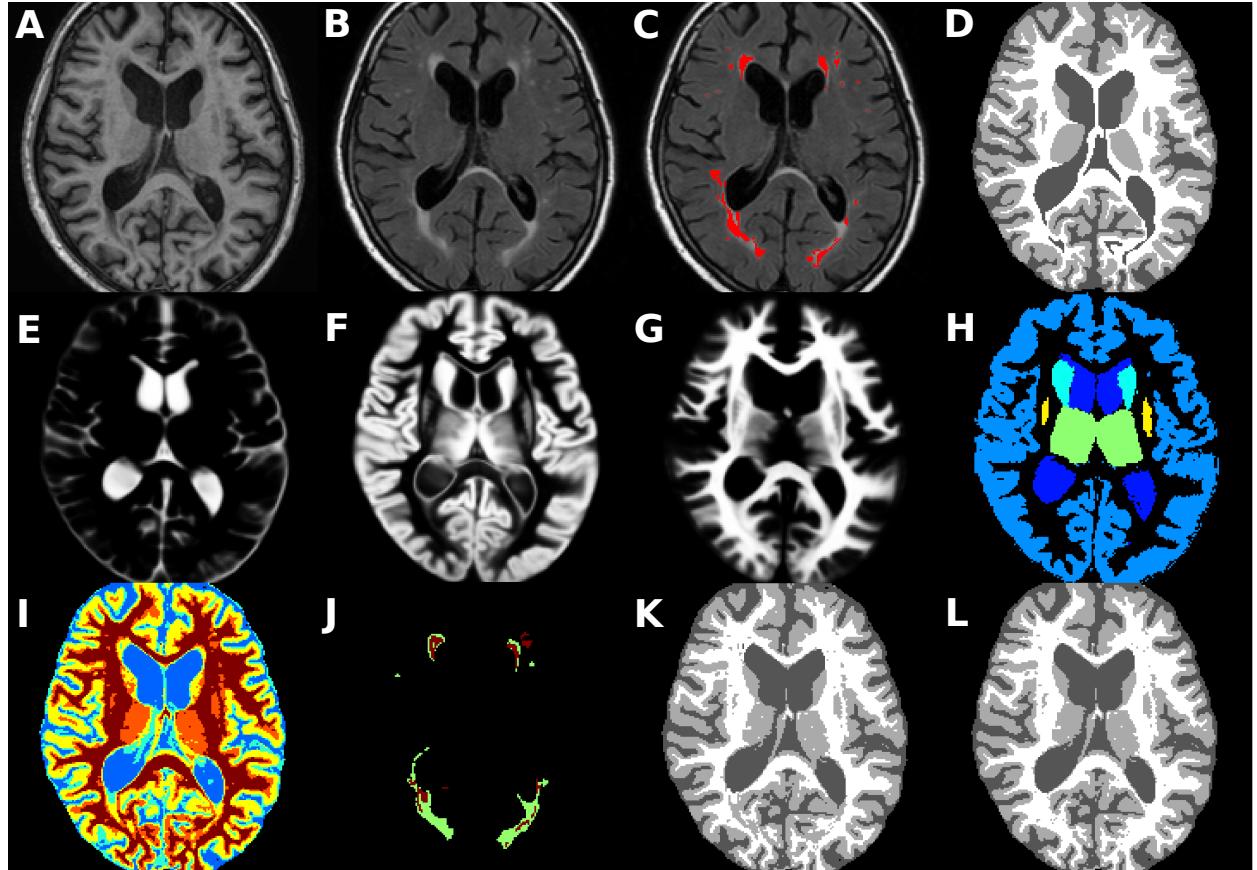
Automated tissue segmentation of the *MSSEG* method on the *second subject* of the training set of the MRBrainS13 database. A) Original T1-w image. B) Original FLAIR image. C) FLAIR image with manual annotated WM lesions depicted in red. D) Provided ground-truth for training purposes. Registered CSF, GM and WM prior atlas to the subject space (E, F and G, respectively). H) Morphological brain structural atlas registered to the subject space. I) First partial volume segmentation with *csf* depicted in blue, *csfgm* in cyan, *gm* in yellow, *gmwm* in orange and *wm* in red. J) Obtained WM outliers extracted from either T1-w (depicted in red) and FLAIR (depicted in green). K) Final tissue segmentation using only the T1-w image, with CSF depicted in dark gray, GM in light gray and WM in white. L) Final tissue segmentation when using both T1 and the FLAIR images.
